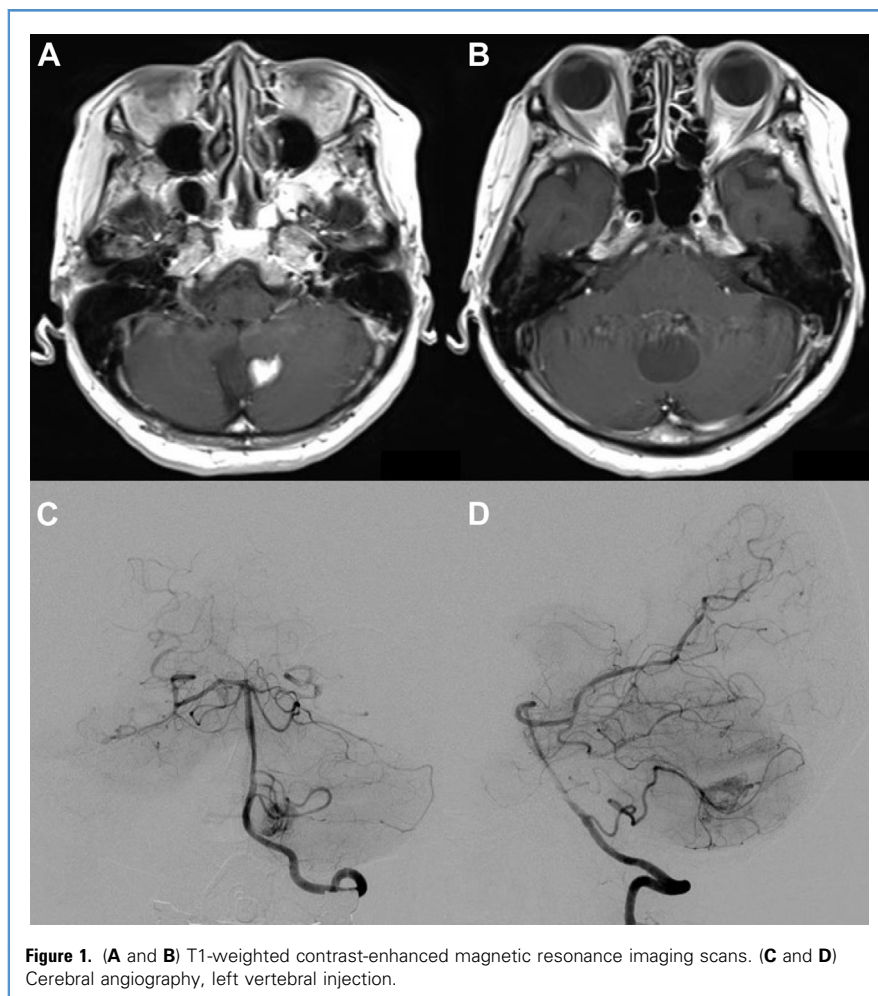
(A and B) T1-weighted contrast-enhanced magnetic resonance imaging scans. (C and D) Cerebral angiography, left vertebral injection.
